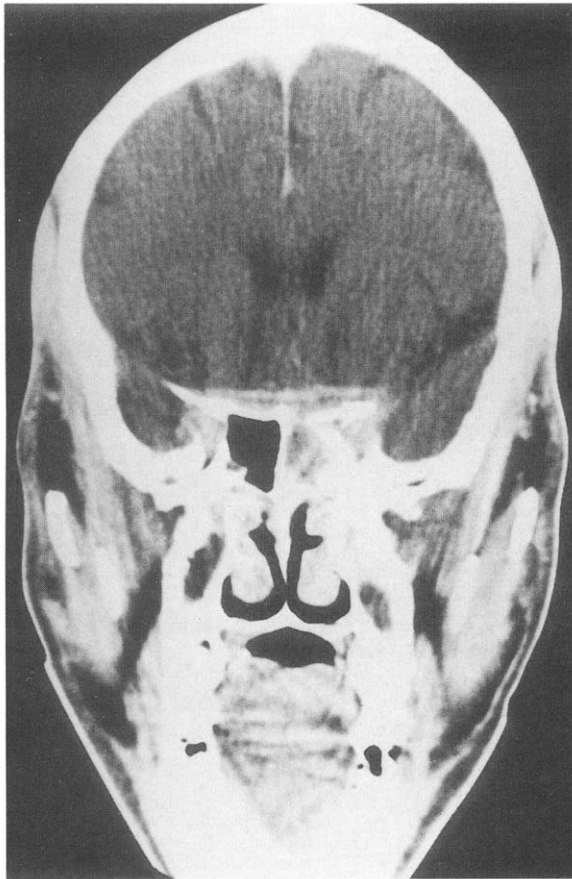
Contrast-enhanced coronal CT scan of case 1. The abscess involves the left sphenoid sinus and extends intracranially to the posterior part of the anterior cranial fossa, lining the frontal base.
